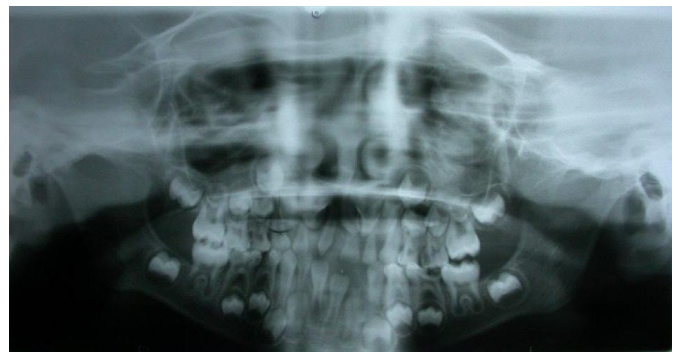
Orthopantomograph showing developing supernumeraries in relation to permanent maxillary first molars on both the sides.
